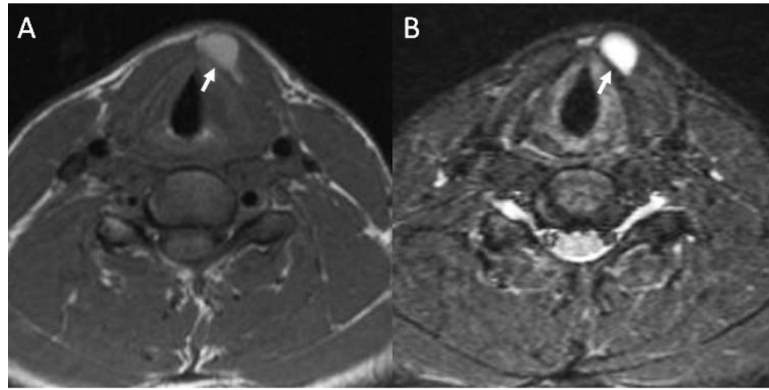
Axial T1-weighted (A) and fat-suppressed T2-weighted (B) MR images of a child with an infrahyoid thyroglossal duct cyst. The images demonstrate a thin-walled cystic structure embedded within the left strap muscles (pathognomonic feature) in an off-midline position. The axial T1-weighted image (A) shows hyperintense signal intensity of the cyst content reflecting intralésional proteinaceous material.
